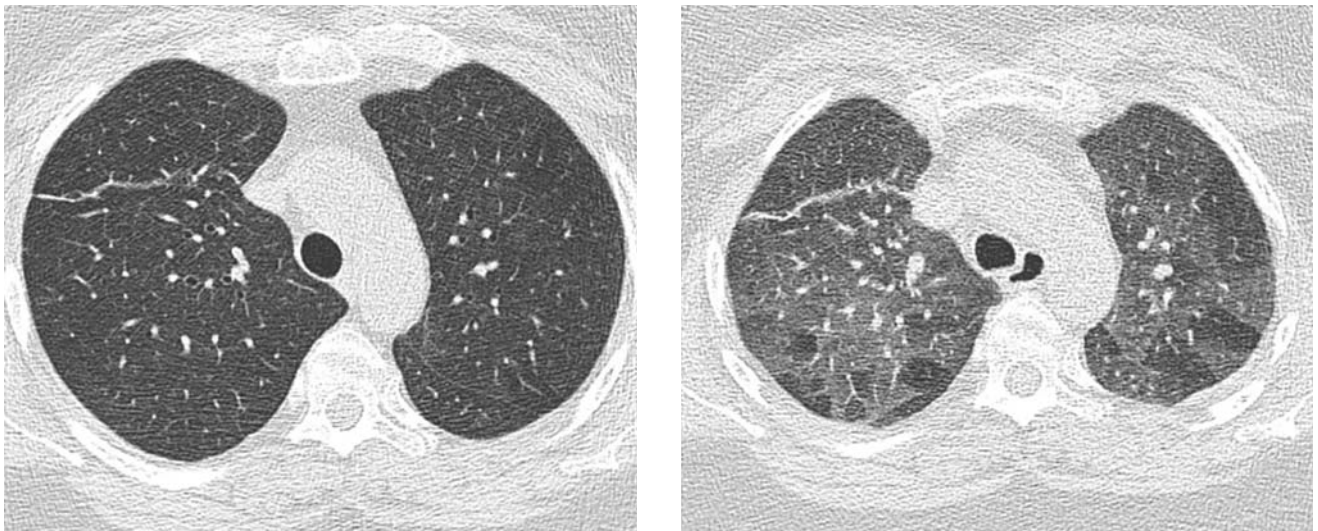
Inspiration (a) and expiration (b) CT scans. Multiple large areas of air-trapping are seen in both lungs
